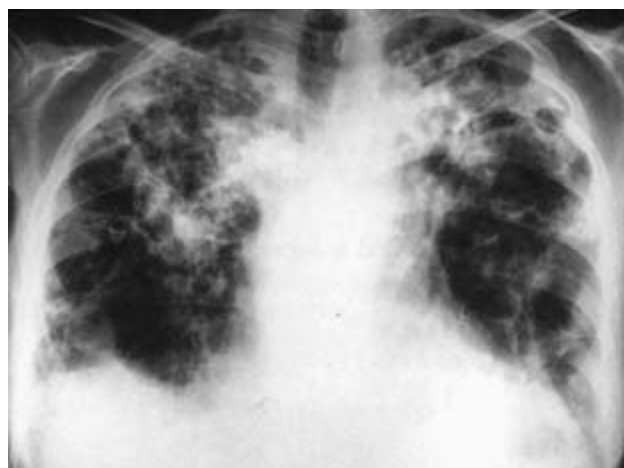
Chronic sarcoidosis with portal hypertension. Chest X-ray of a woman aged 45 shows bilateral, severe, end-stage pulmonary fibrosis.
